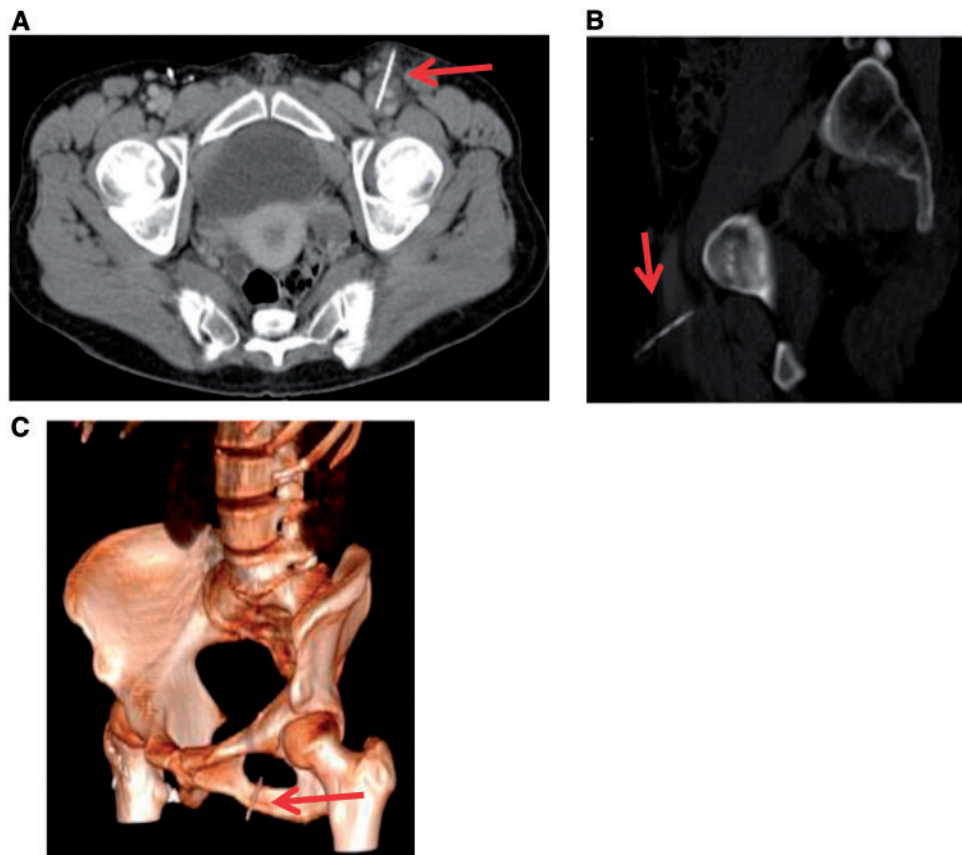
(A) Pelvic computed tomography scan, cross section; (B) pelvic computed tomography scan, sagittal section; (C) computed tomography scan, 3D reconstruction; showing a 4-cm long extra-vascular foreign body lodged in the Scarpa's triangle. (A-C) Red arrows pointing at the needle.
